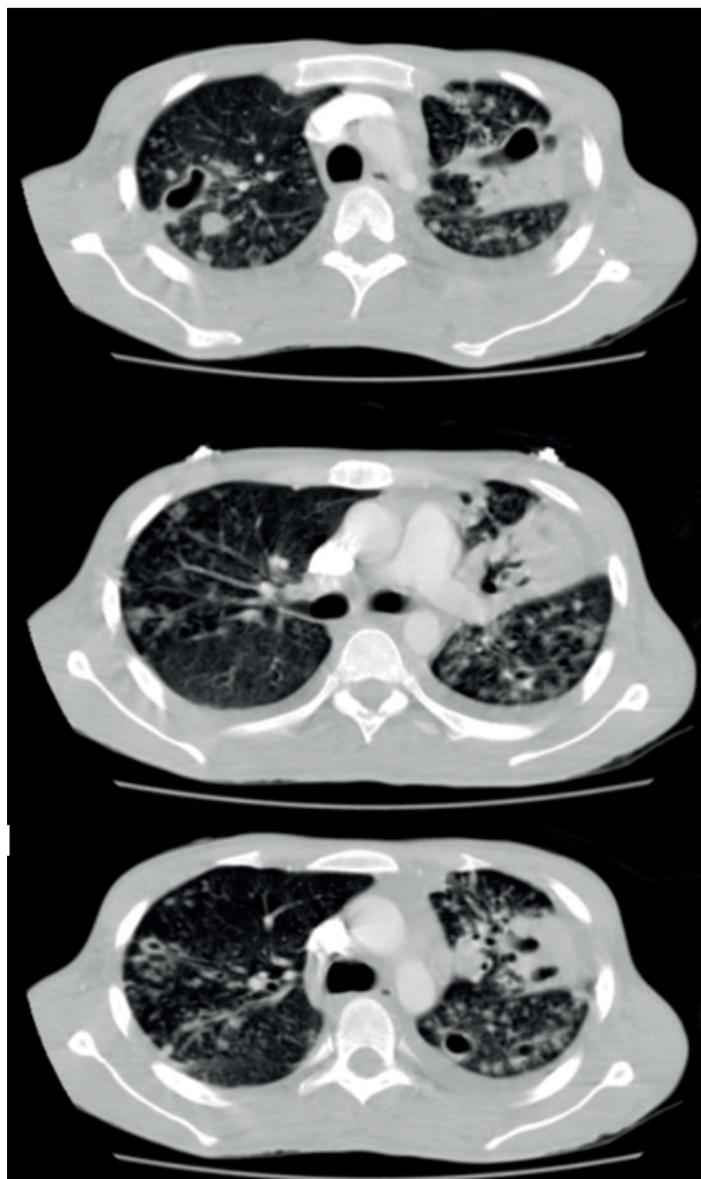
Chest computed tomographic scan showing thick-walled cavitated lesions in the upper lobes.
